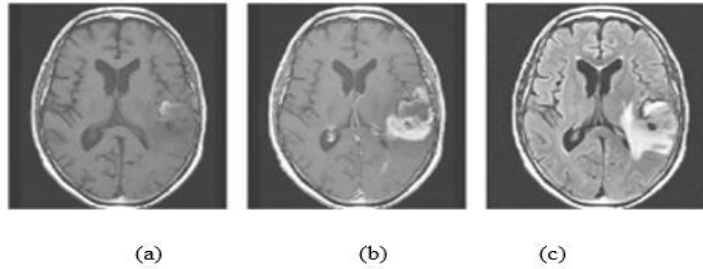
A tumor with ring enhancement. a) Axial brain imaging slice using T1-weight. b) The identical T1-weight brain imaging slice boosted by contrast. c) FLAIR cerebral imaging
